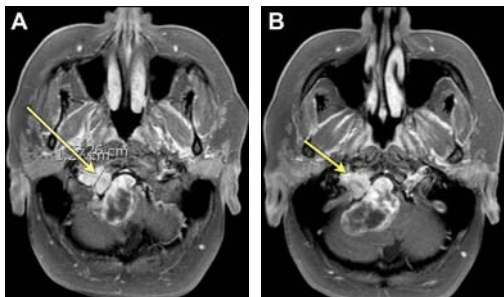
Preoperative axial MRI with contrast showing the same lesion on the right side
